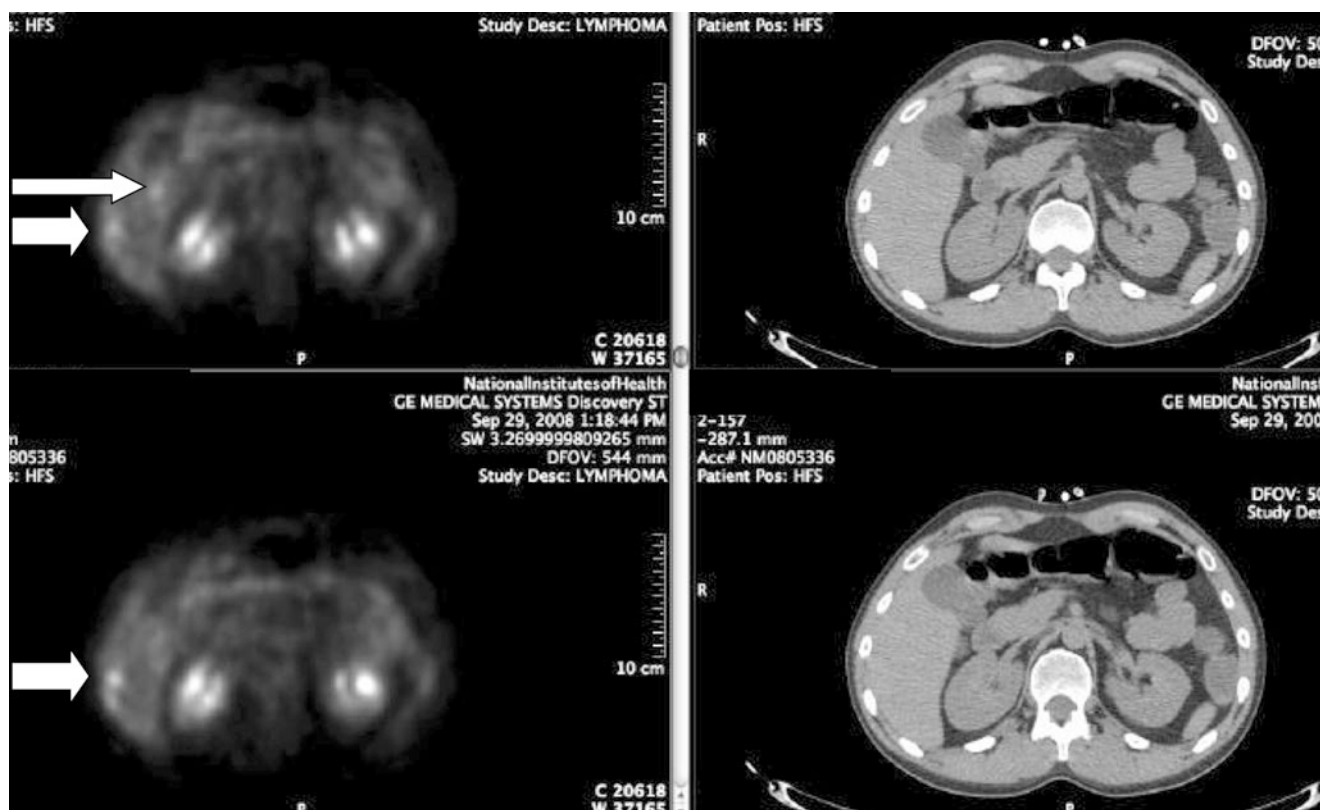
EBV-related lymphoproliferative disorder after a matched unrelated donor transplant. A 24-year-old man with Hodgkin lymphoma underwent a syngeneic HCT followed by MUD HCT (cyclophosphamide + fludarabine followed by alemtuzumab and cyclosporine). His day-28 CT/PET showed a mixed response: improvement in the intrathoracic lesions and cervical lymph nodes but appearance of new PET+ lesions in the liver, pharynx, and stomach. EBV viral load had been increasing slowly. Biopsies of the PET+ liver and stomach lesions showed a polyclonal EBV+ B cell infiltrate. The disease responded to rituximab and cyclosporine taper.
